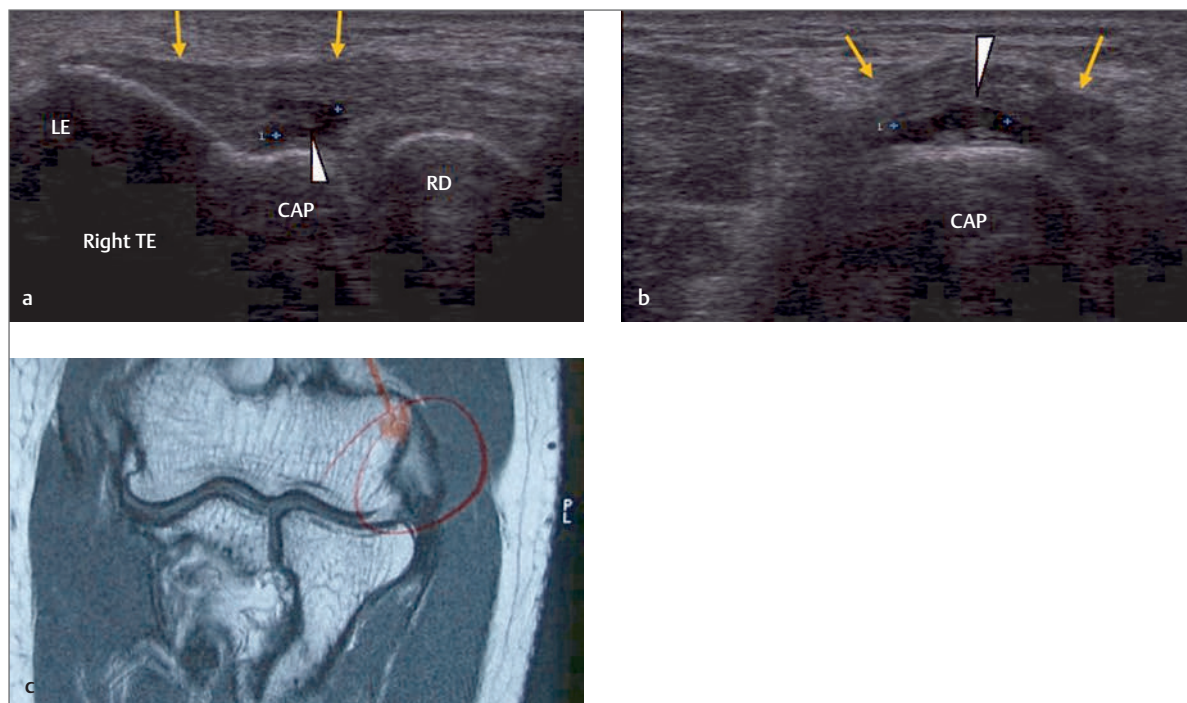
(a) Longitudinal image of the lateral elbow demonstrating a hypoechoic region (*white arrowhead*) within the deep aspect of the common extensor tendon in keeping with a tear. The tear can be seen to for a “backward-C” shape between the two caliper markers. (b) Transverse image of the same patient as in part (a). The hypoechoic region (*white arrowhead*) deep within the tendon can be seen to extend almost the entire width of the tendon. (c) Magnetic resonance imaging (MRI) (T1 coronal) of the same elbow as outlined in parts (a) and (b). Although the MRI demonstrates increased signal within the common extensor tendon the US images are able to give more information in regard to an actual tear and its size. CAP, capitulum; LE, lateral epicondyle; RD, radial head; white arrowhead, tear; yellow arrows, common extensor tendon.
